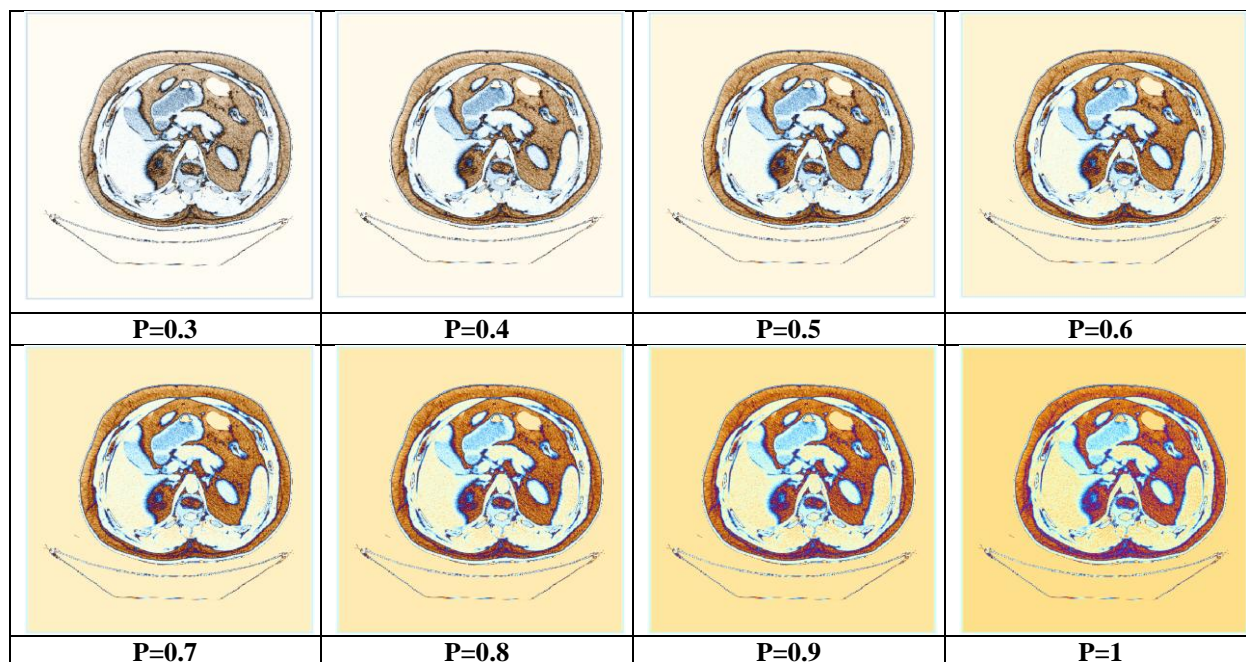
The color output CT-Scan images with different P values
